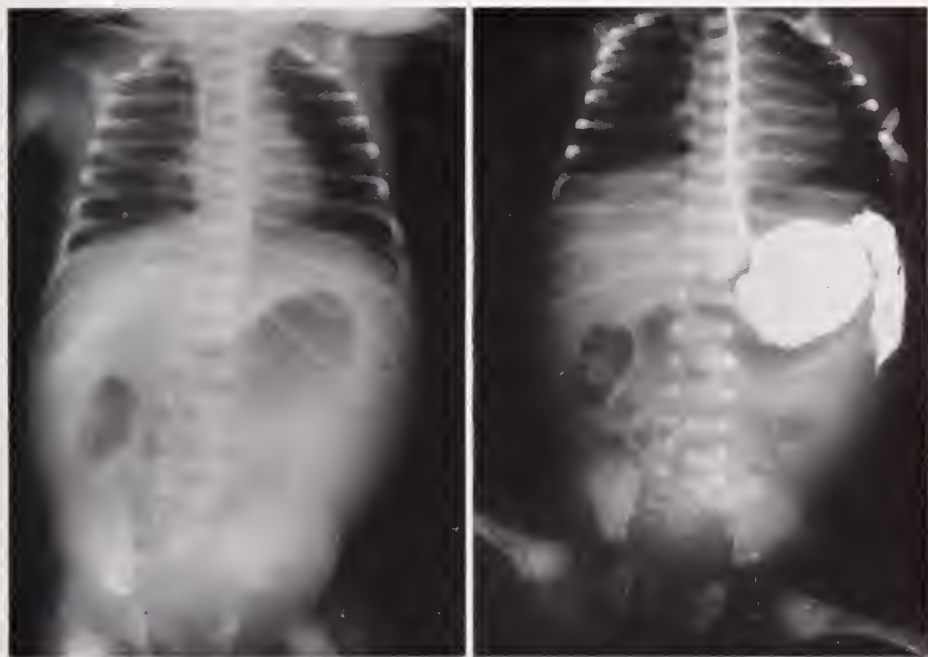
(Left) Plain film of the abdomen in supine position, revealing a diminished intestinal gas pattern. An air shadow over the mid-epigastrium, suggesting free air in the peritoneal cavity, can be recognized with difficulty.
